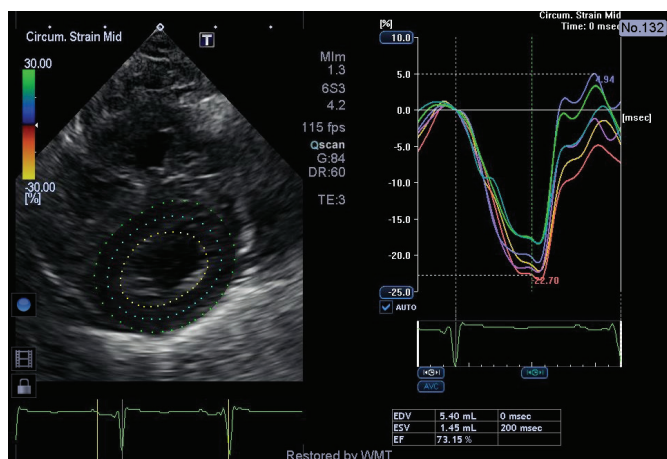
Global circumferential strain—parasternal short axis view at the left ventricular mid-cavity level.
